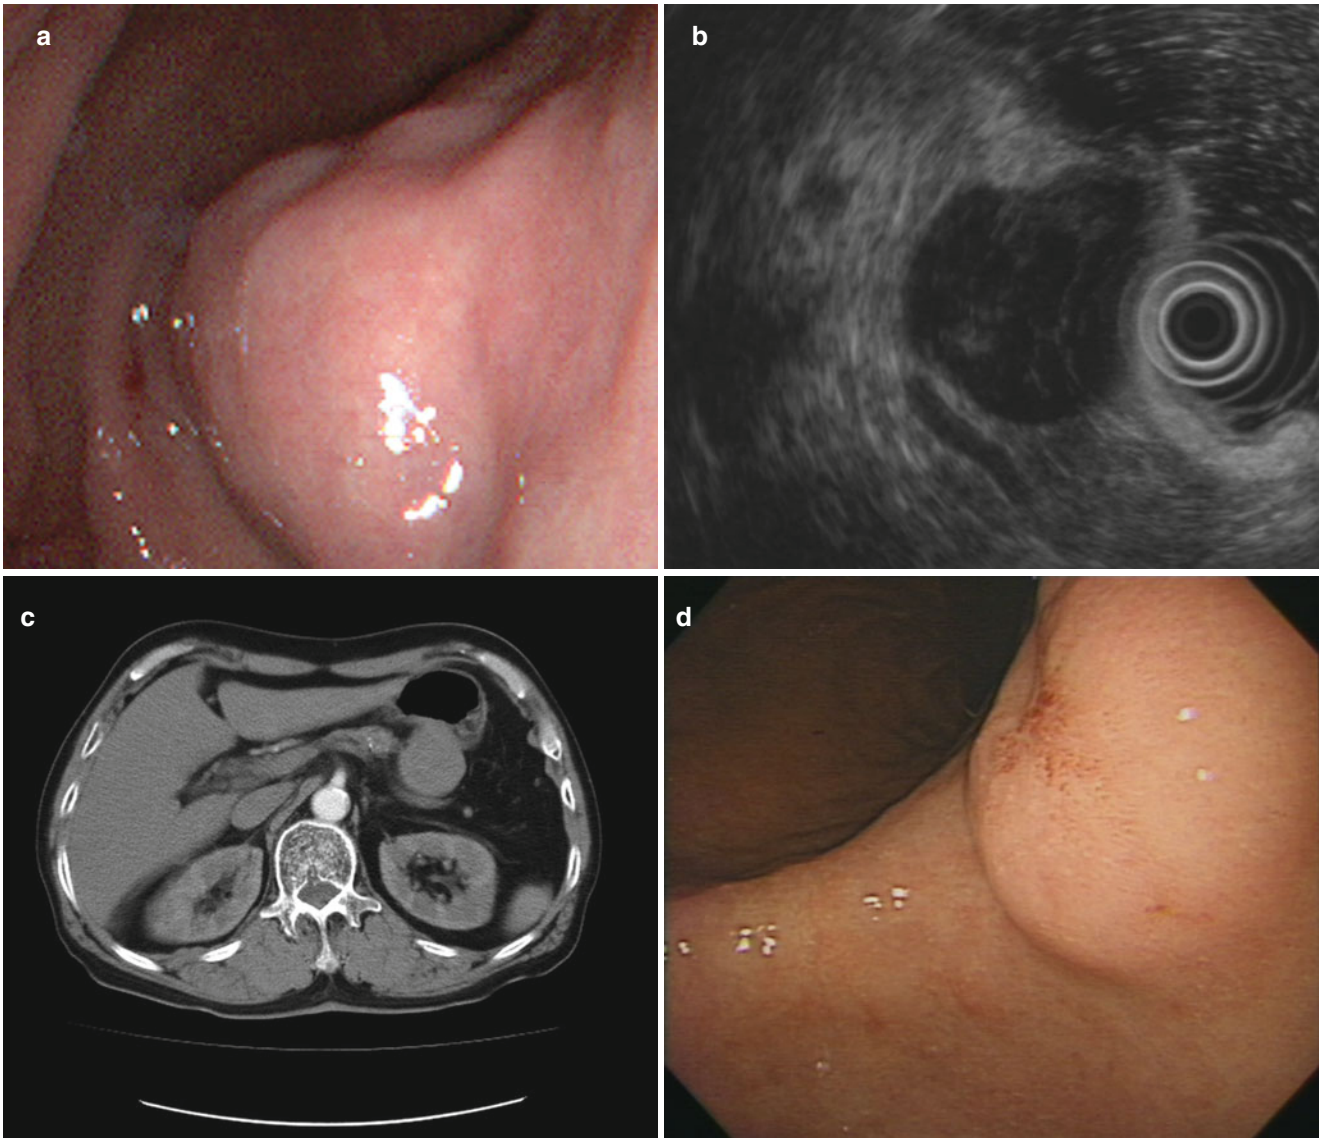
Gastric leiomyosarcoma. (a) About 4-cm subepithelial mass was noted on posterior wall of the mid-body. (b) Hypoechoic heterogeneous mass was noted on the back of gastric wall. It looks like an originating mass from the outer circular muscle layer. It was mainly located in the tail of the pancreas. It has hyperechoic septum and lobulated contour. It was measured by 46×42 mm in diameter. (c) Abdomen CT
